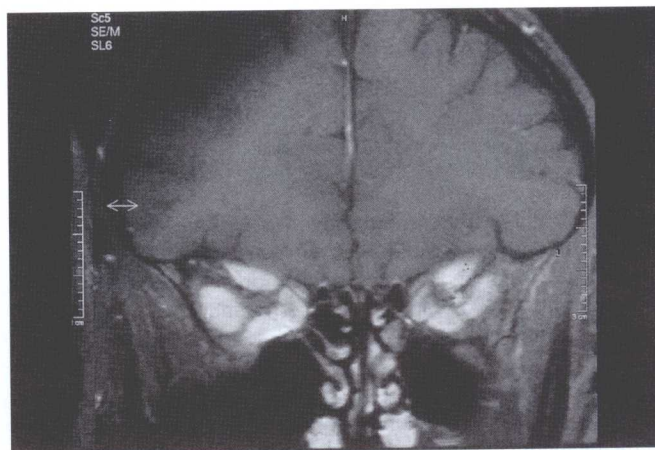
Magnetic resonance imaging (MRI) scan of coronal view of the orbit, showing enlarged muscles in thyroid disease (courtesy of Dr Juliette Britton).
